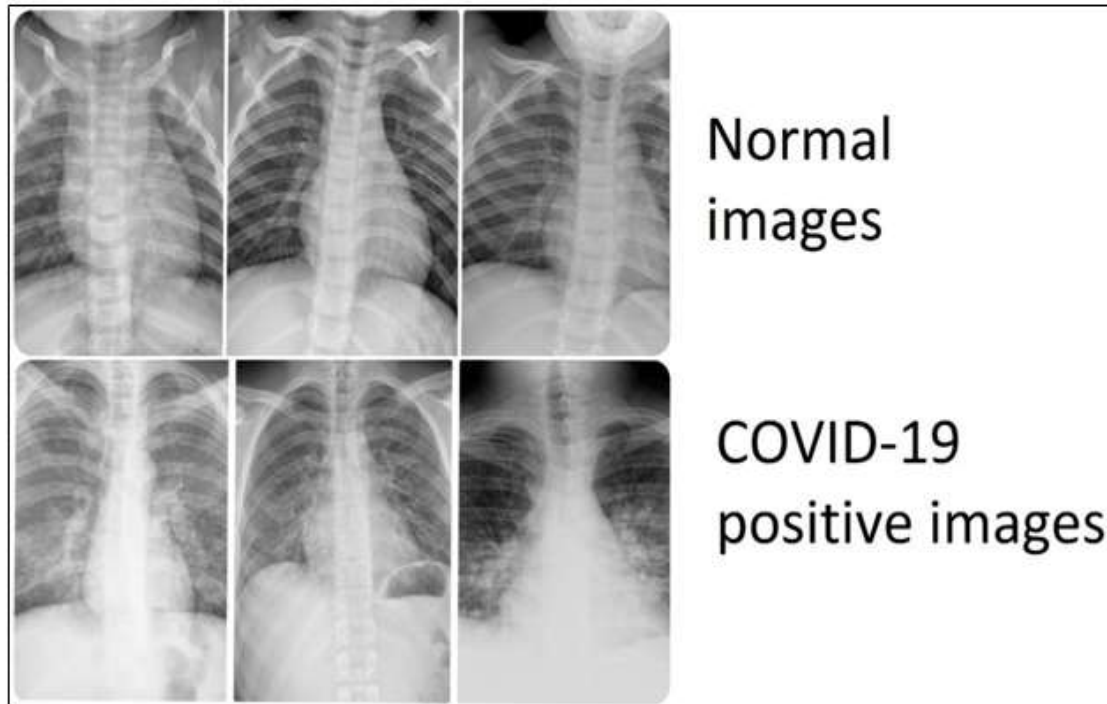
Representative chest X-ray images of normal (first row) and COVID-19 (second row).
